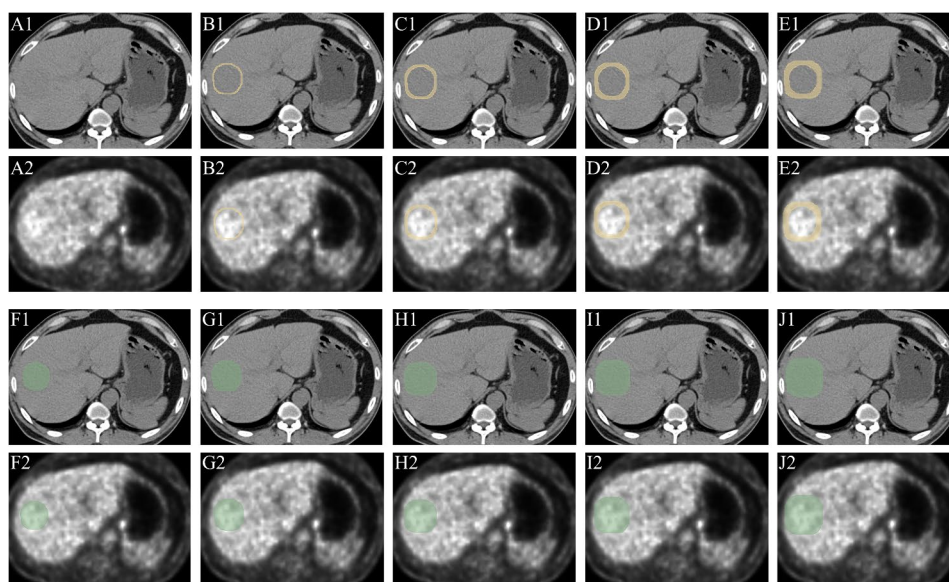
The representative PET/CT images and corresponding delineations of VOIs. (A) The original CT (upper) and PET (lower) images. The delineations of peritumor regions (PTRs) within a 2 mm (B), 4 mm (C), 6 mm (D), and 8 mm (E) thickness to the tumor boundary in CT images (upper) and PET images (lower). (F) The delineation of intratumoral region (TR) in CT images (upper) and PET images (lower). The segmentations of integrated intratumoral and peritumoral regions (TR-PTR) based on TR delineation with automatic dilated PTR with thicknesses of 2 mm (G), 4 mm (H), 6 mm (I) 8 mm (J) in CT images (upper) and PET images (lower)
